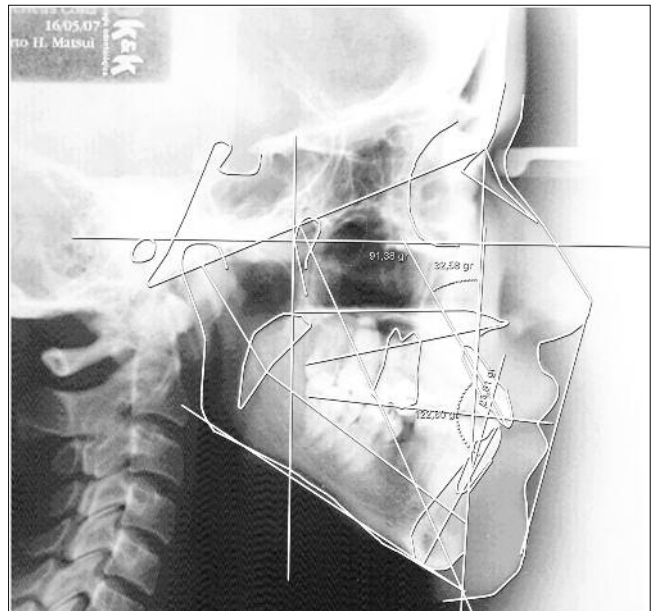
Ricketts' cephalometric analysis in a digital radiography obtained by indirect method
